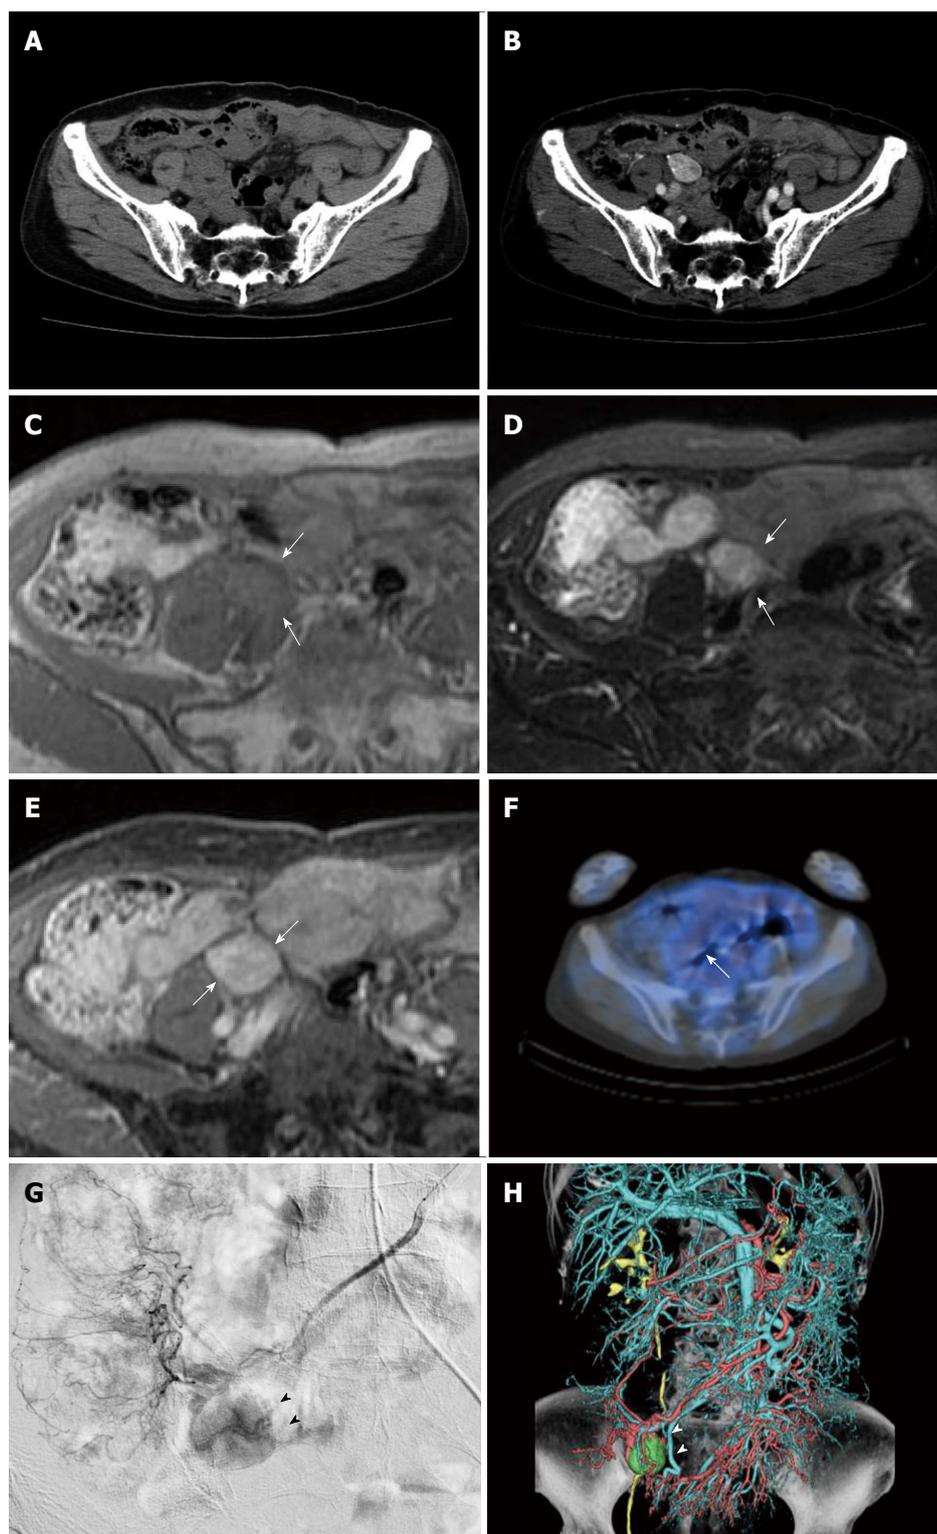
Imaging features of tumor (white arrows) before treatment. A: Axial plain; B: contrast-enhanced computed tomography (CT), CT shows a smoothly margined, heterogeneously enhanced tumor adjacent to the right major psoas muscle, 16 mm × 22 mm × 25 mm in size; C: T1-weighted magnetic resonance image shows a well defined, isointense mass; D: On T2-weighted images, the mass shows heterogeneous high intensity; E: On T1-weighted images after a bolus infusion of gadolinium chelate, the mass had marked contrast enhancement; F: Positron emission tomography-CT scan was negative; G: Superior mesenteric arteriography displays a markedly hypervascular mass (black arrow heads) adjacent to the terminal ileum; H: Volume rendering image acquired from angio-CT (white arrow heads).
